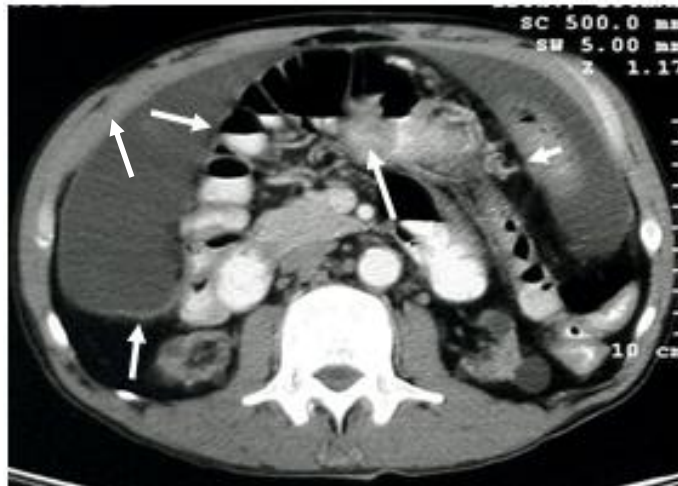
Abdominal computed tomography image with contrast showing focal peritoneal thickening, dilatation and air-fluid levels in the loops of the small bowel, collection of small bowel loops in the midline abdomen and focal fluid collection between the small bowel loops (arrows).
